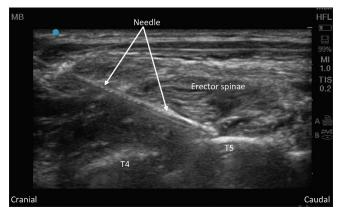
Ultrasound-guided continuous retrolaminar block. The figure shows the entry of a needle, coming into contact with the T5 lamina
